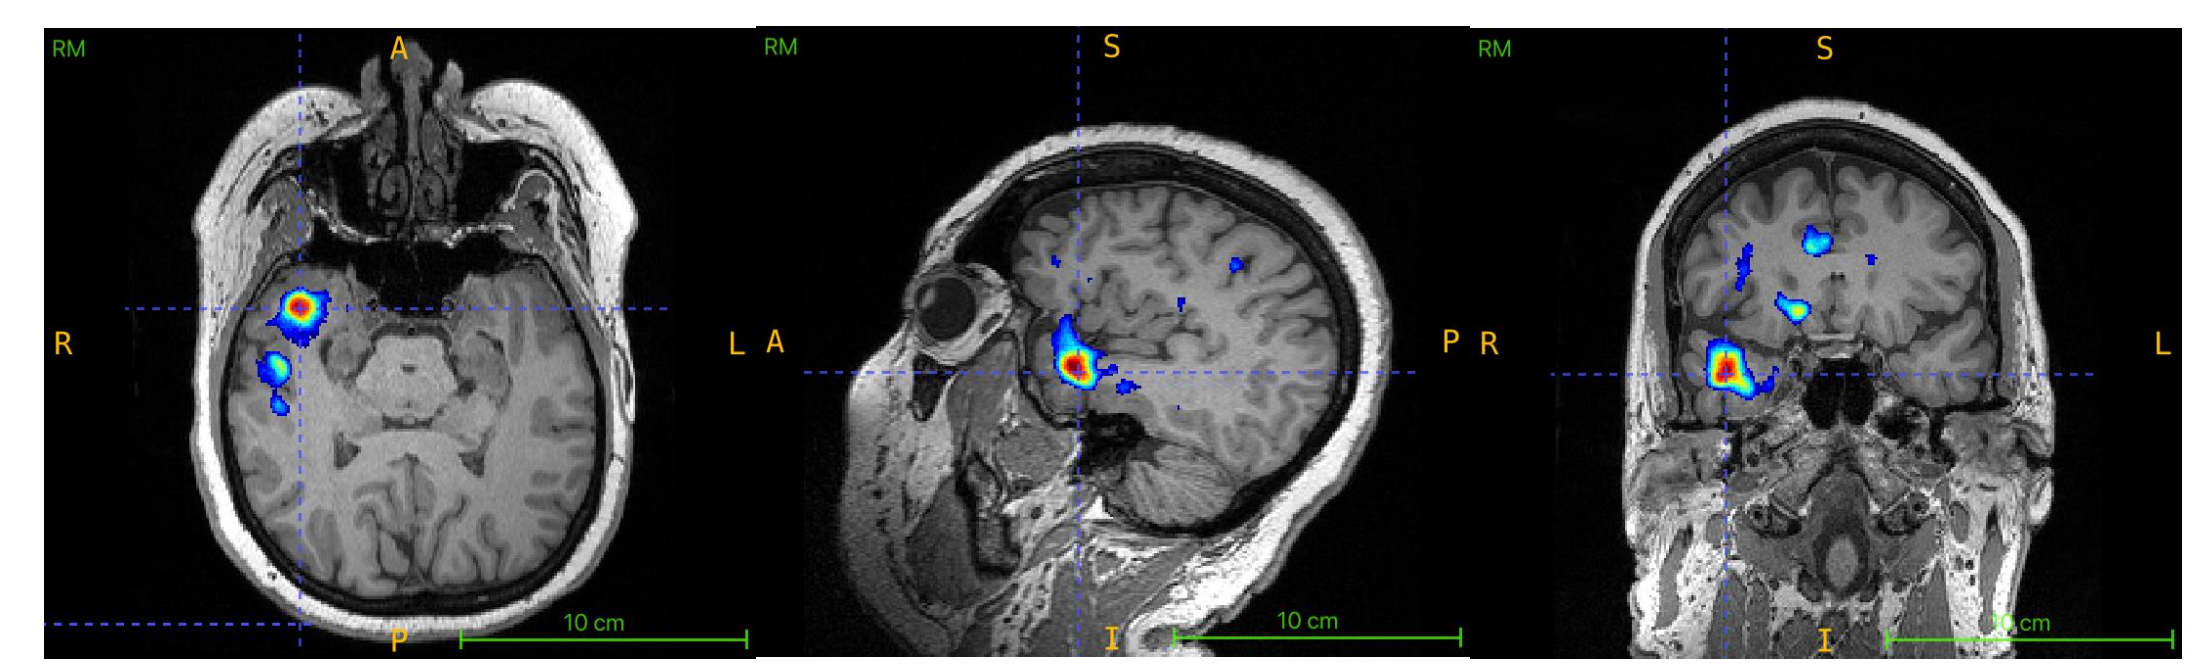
Epileptogenic focus localized on the MRI using the mean normalization method.
